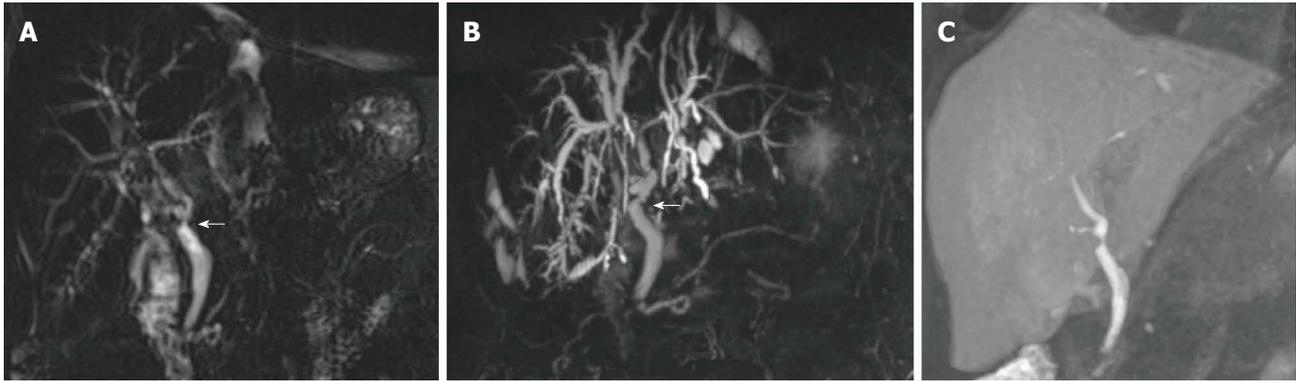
Technical variants of magnetic resonance cholangiography, as shown in coronal images of a 66-year-old male patient transplanted for alcoholic cirrhosis. A: Conventional, T2-weighted 2D MRC; B: MIP reconstruction from conventional, T2-weighted 3D MRC; C: Thick MIP reconstruction from T1-weighted, contrast-enhanced MRC. Both the degree and functional significance of the mild anastomotic stricture indicated by arrows are better showed by contrast passage in (C). MRC: Magnetic resonance cholangiography; MIP: Maximum intensity projection.
